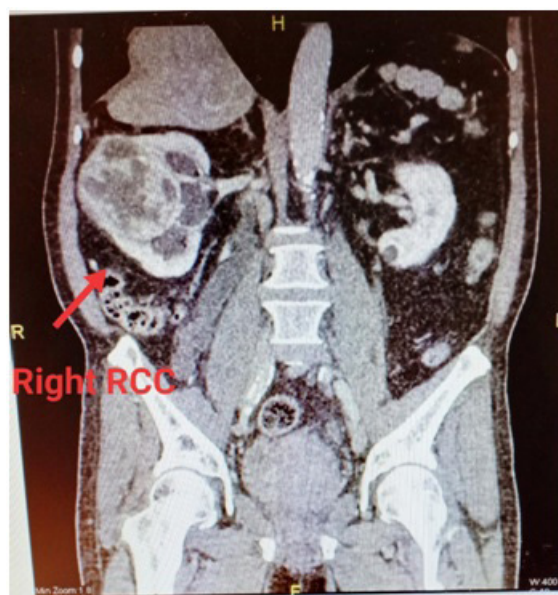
CT renal 4 phase showed a lobulated enhancing mass at interpole of right kidney measuring 8.8 x 6.6 x 8.6 cm suggestive of right renal cell carcinoma
